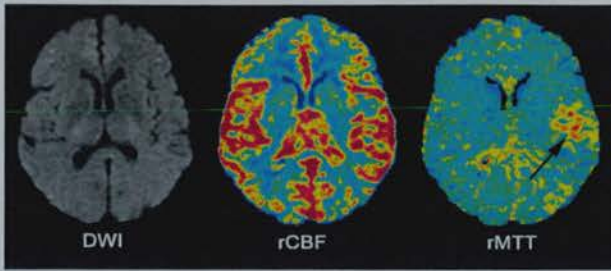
A patient with a visible PI lesion but no DWI lesion
